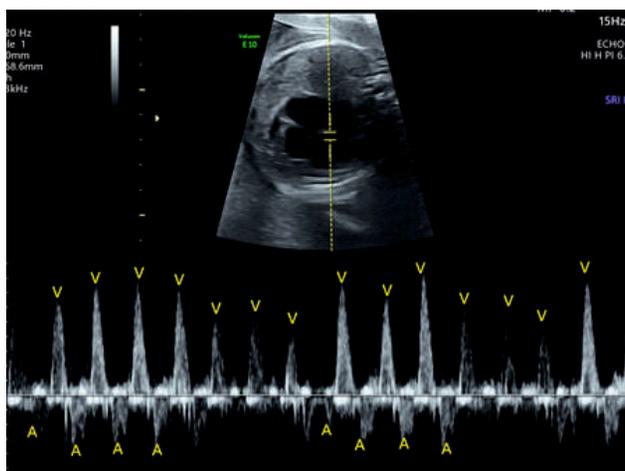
Fetal LVOT Doppler showing multiple ventricular premature beats, not preceded by atrial activity
